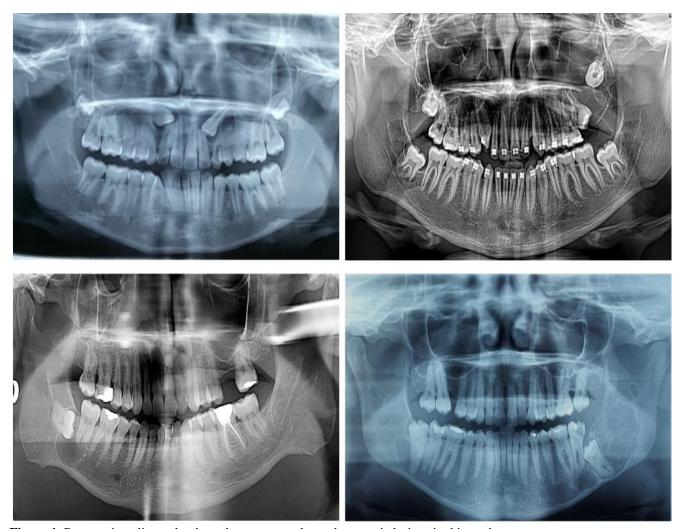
Panoramic radiographs show the most prevalent odontogenic lesions in this study.
